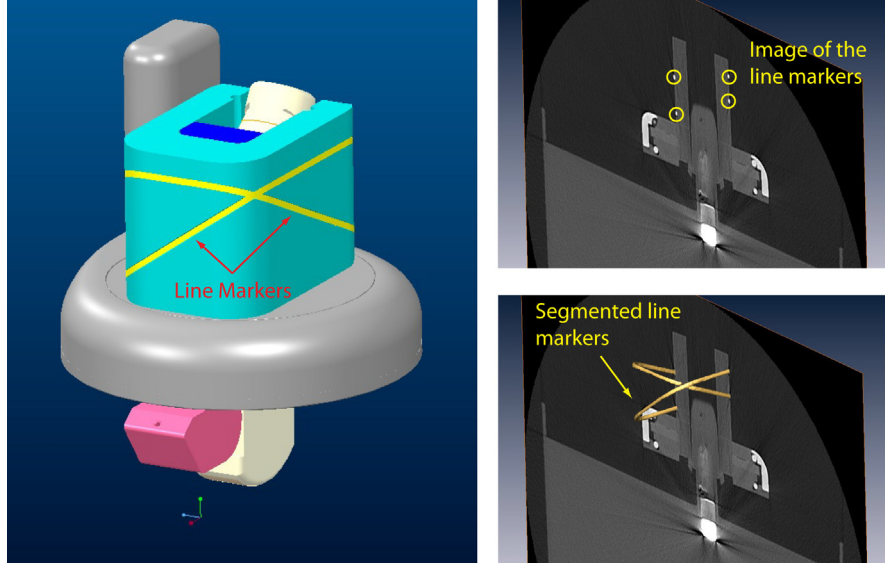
Registration marker and its CT image
